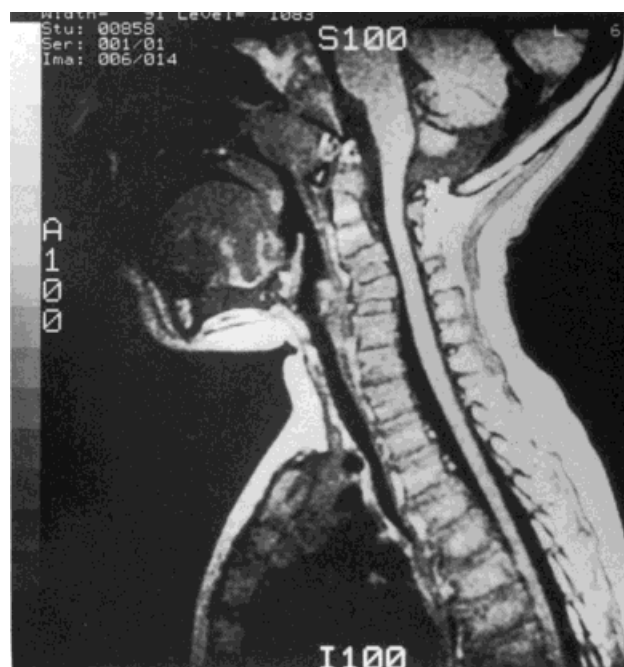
Three-year-old with spondyloepiphyseal dysplasia (SED) congenita. The MRI of the cervical region reveals C<sub>3</sub>, C<sub>4</sub>, C<sub>5</sub> posterior subluxation with cord compression in the neutral position.
